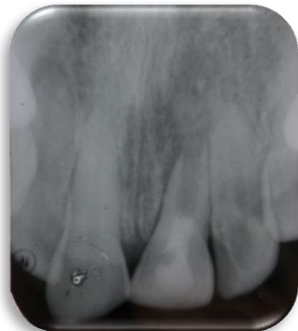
showing 1 1/2 years follow up post operative radiograph
